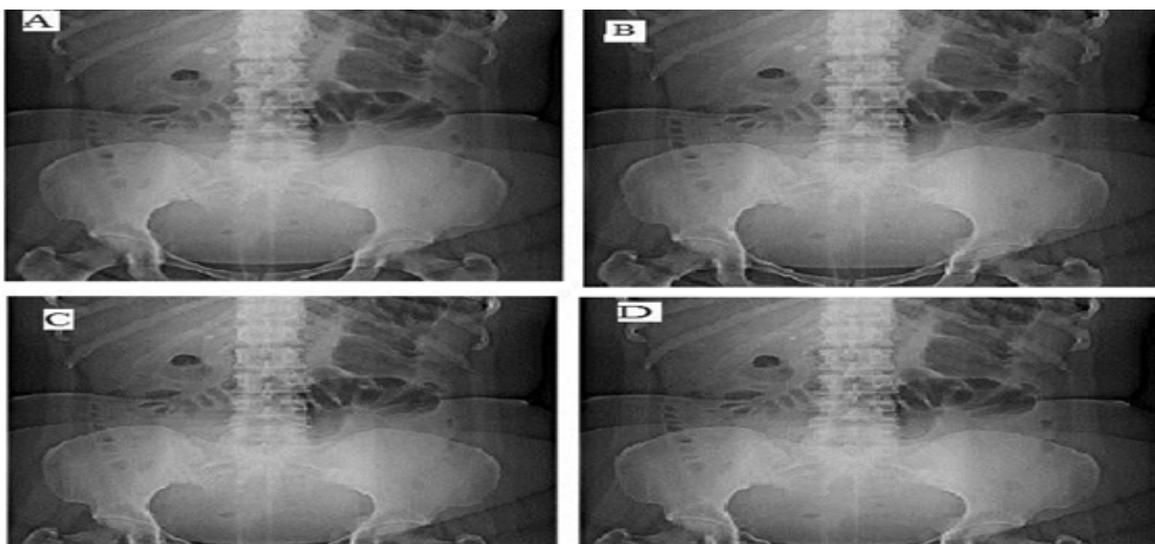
8. X-Ray of formulation F6 after time interval (A) 1 hr; (B) 2 hrs; (C) 4 hrs; (D) 6 hrs
